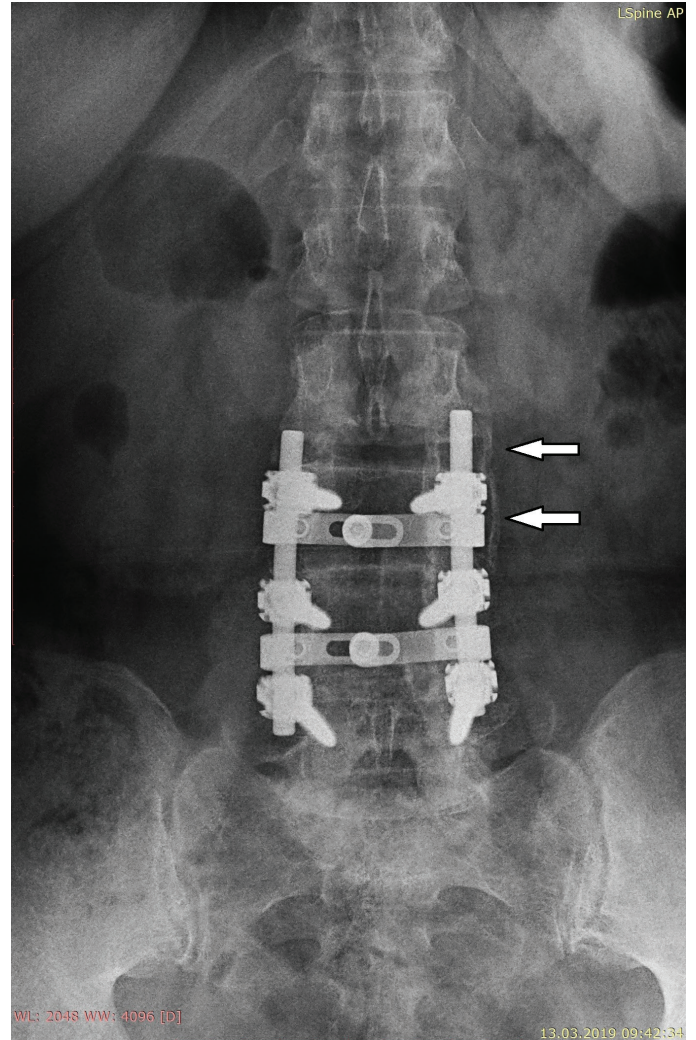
Stage 1 fusion. Some bony bridging is noted between transverse processes (white arrows) on the posteroanterior lumbar roentgenography, indicating incomplete fusion
